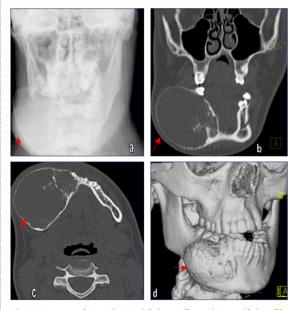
Images of a patient with juvenile active ossifying fibroma of the right body of mandible. (a) posterio-anterior plain radiograph, (b) coronal CT, (c) axial CT and (d) 3-D reconstructed CT views.
